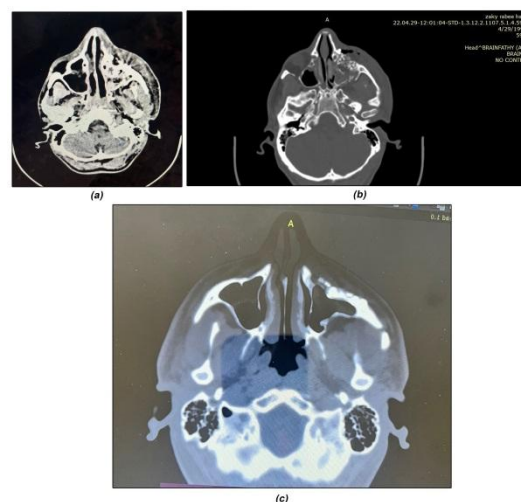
a- immediate post operative axial view of CT scan of reconstructed orbital floor with coated titanium mesh, b- axial view of CT scan of one month postoperative of reconstructed orbital floor with coated titanium mesh, c- axial view of CT scan of 3 month postoperative of reconstructed orbital floor with coated titanium mesh.
